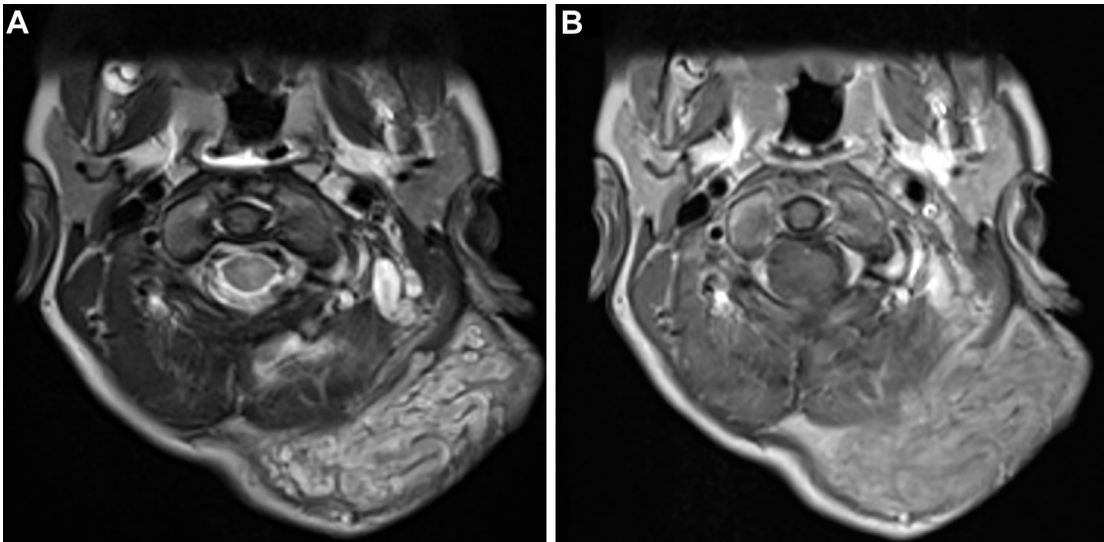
Plexiform neurofibroma in a 12-year-old female patient with NF1. (A) Axial T2WI shows bag-of-worms appearance in the left suboccipital region. (B) Contrast-enhanced axial T1-weighted image shows diffuse heterogeneous enhancement.
